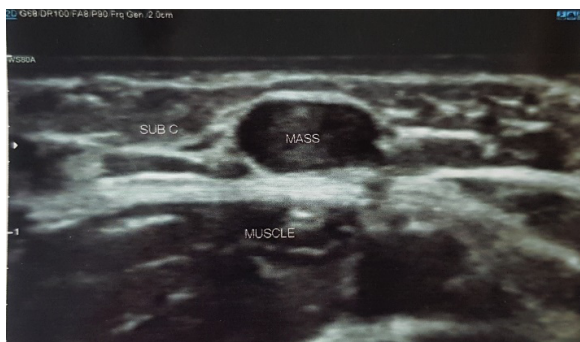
The sonographic representation of the subcutaneous mass
